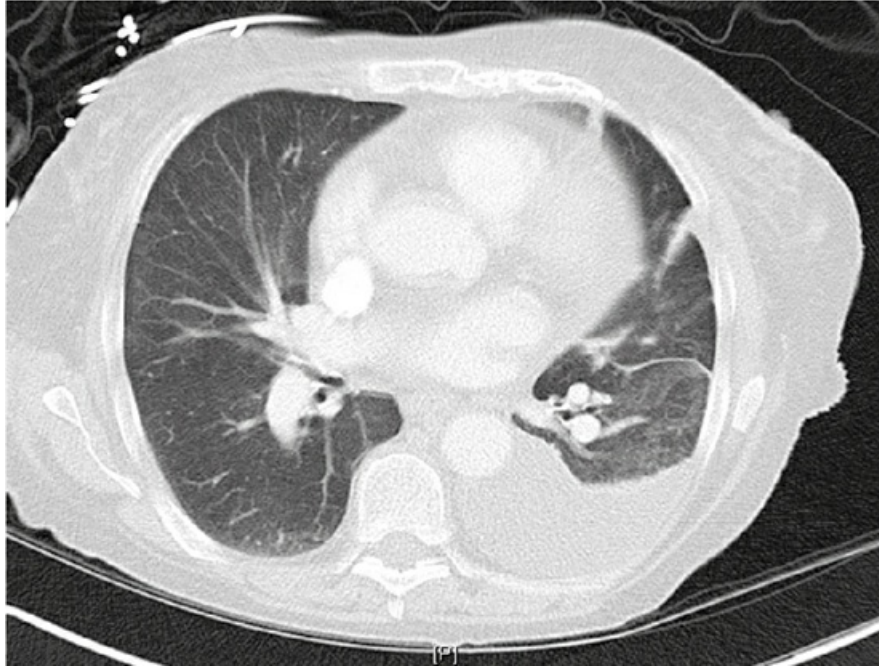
Chest computed tomography scan showing a left pleural effusion. With the patient supine, the fluid lies posteriorly against the chest wall in the dependent portion of the left hemithorax.
